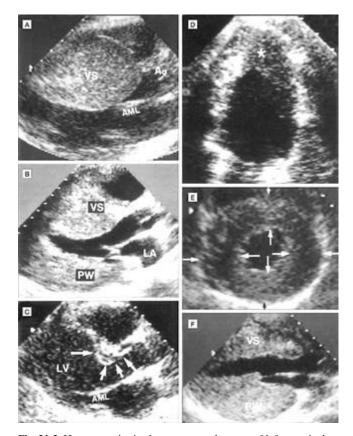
Heterogeneity in the pattern and extent of left ventricular (LV) wall thickening in hypertrophic cardiomyopathy (HCM). Echocardiographic parasternal long-axis images obtained in diastole showing A, massive asymmetric hypertrophy of ventricular septum VS with wall thickness > 50 mm; B, pattern of septal hypertrophy in which the distal portion is considerably thicker than the proximal region at mitral valve level; C, hypertrophy sharply confined to basal (proximal septum) just below aortic valve (arrows); D, hypertrophy confined to LV apex (asterisk), consistent with the designation of apical HCM; E, relatively mild hypertrophy in a concentric (symmetric) pattern with each segment of ventricular septum and LV free wall showing similar or identical thicknesses (paired arrows); F, inverted pattern of hypertrophy in which anterior VS is less substantially thickened than the posterior free wall (PW), which is markedly hypertrophied (i.e. 40 mm). Calibration marks are 1 cm apart. Ao, aorta; AML, anterior mitral leaflet; LA, left atrium. (Reprinted from Klues et al.,⁶⁷ Copyright (1995), with permission from The American College of Cardiology Foundation.)
